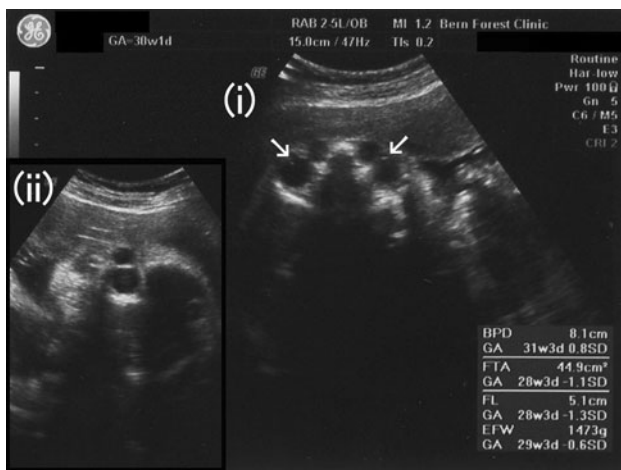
Ultrasonographic findings at 30⁺¹ weeks' gestation. *i* Axial view of the fetal head shows bilateral, uniloculated, anechoic and avascular orbital cystic "lesions" with thin walls inferomedial to the eyeballs. Lenses are observed in the eyeballs (white arrows), but not in the cysts. The right cyst is 7.4 mm × 7.8 mm and the left cyst is 7.6 mm × 8.1 mm in size. *ii* Sagittal view of the fetal head shows that there is no mass effect on the orbit
